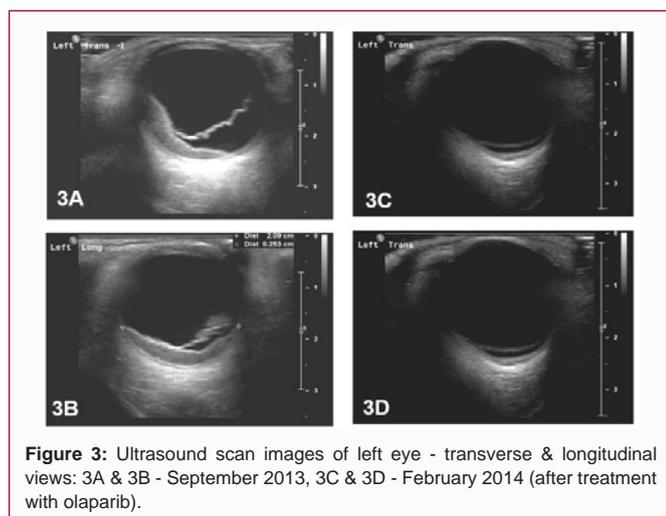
Ultrasound scan images of left eye - transverse & longitudinal views: 3A & 3B - September 2013, 3C & 3D - February 2014 (after treatment with olaparib).
